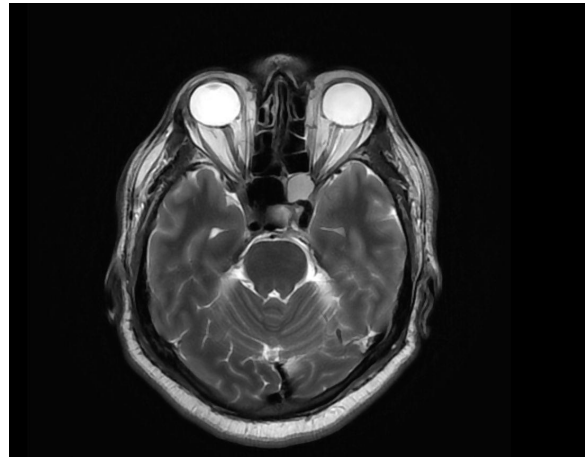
Pre-operative MRI brain (axial T2-weighted image) showing a hyperintense lesion within the sphenoid sinus consistent with a sphenoid mucocele, extending toward the posterior ethmoid region (Onodi cell) and abutting the left optic canal.
